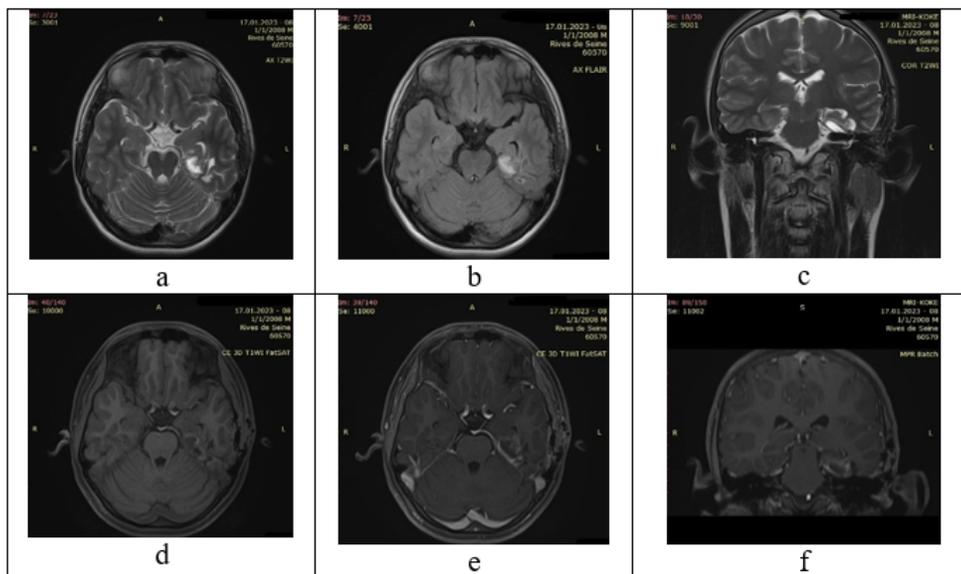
MR images one month after the surgical resection reveal a well-limited postoperative parenchymal defect, mostly homogeneous, with porencephalic cystic components in the left temporal lobe, without peritumoral edema. Axial T2 images show porencephalic cystic components approximately 14x8mm, very hyperintense, with the expansion of the left temporal horn (a). Axial Flair presents postoperative cicatricial edema, not expansive edema (b). Coronal T2 clearly shows the postoperative defect (c). In T1 before the contrast, we notice a hypointense cystic component, while the solid component is not present, there is methemoglobin retention (d), after the gadolinium contrast, we have very discrete pathological marginal enhancement of the postoperative defect (e), while in T1 in the coronal plane after gadolinium is presented the discrete marginal pathological enhancement from the postoperative porencephalic cystic component (f).
